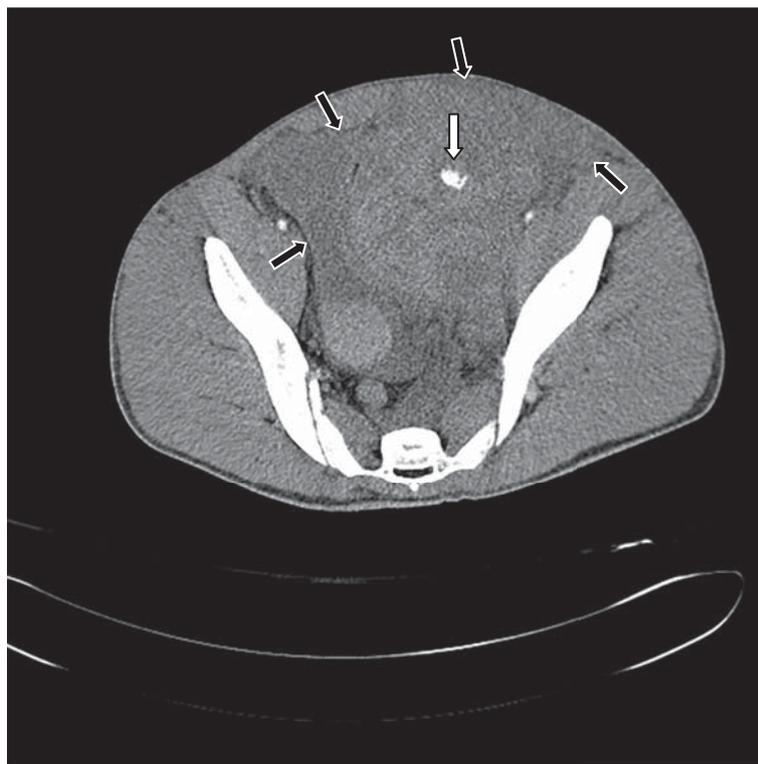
Axial CT scan demonstrating active bleeding (white arrow).
